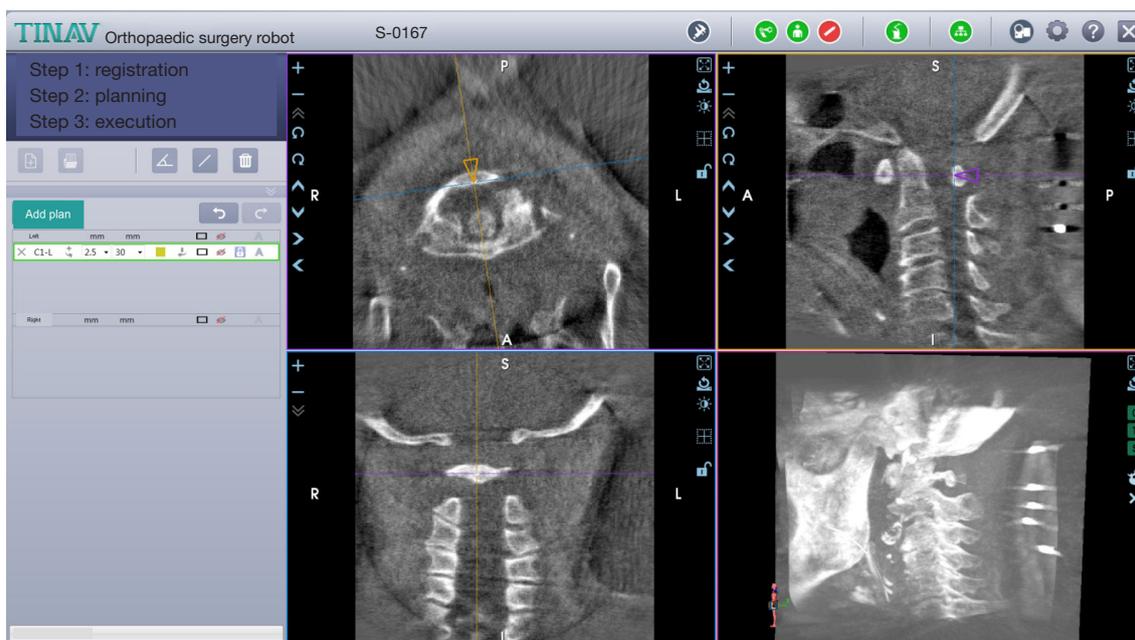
Planning of the puncture path and the anchoring point of the Kirschner-wire were performed on the robotic platform. Pre-operative planning can be observed on the sagittal, cross-sectional, coronal imaging, and three-dimensional reconstructions of the CT. CT, computed tomography.
